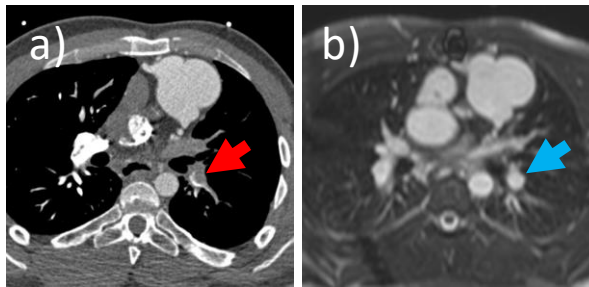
a) CT demonstrates a filling defect within the left pulmonary artery resembling a large PE (red arrow) in a 27-year-old with Fontan circulation. b) Contemporaneous MRI (3D trueFISP) demonstrates no filling defect within the LPA (blue arrow) confirming the CT appearance as a 'pseudo-PE' resulting from poor mixing of contrast opacified blood from the SVC with non-opacified blood from the IVC preferentially filling the left pulmonary artery.
